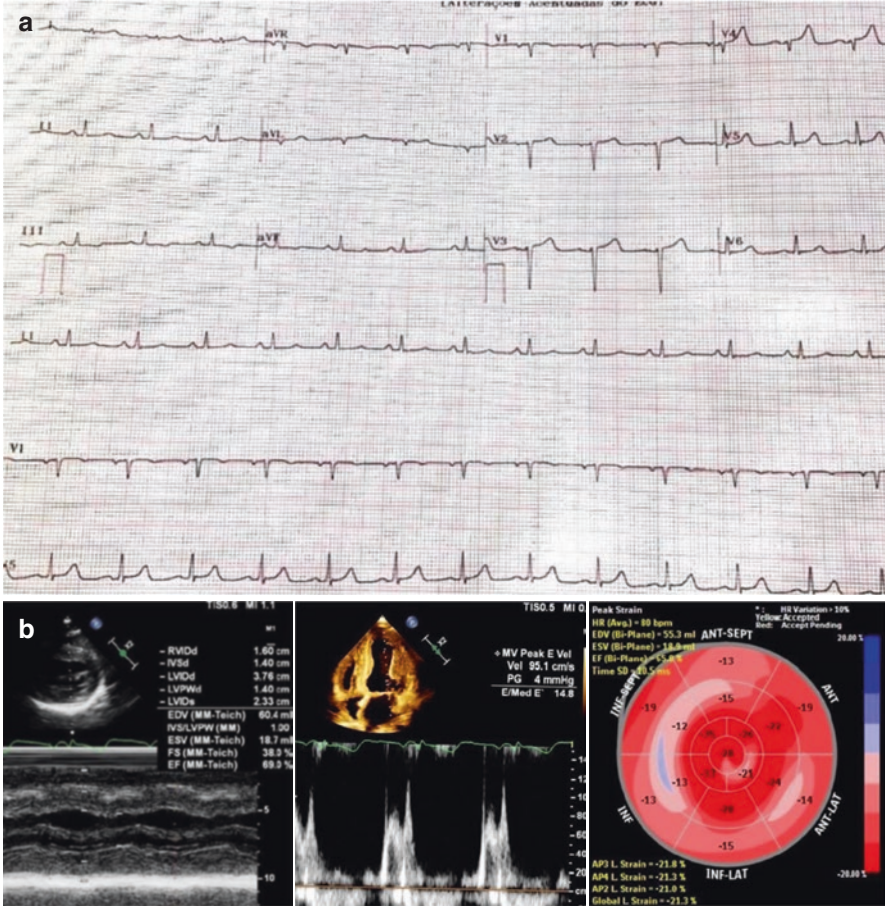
(a) Low-voltage limb leads without left ventricular hypertrophy voltage criteria despite increased wall thickness on echocardiography and pseudoinfarction in anterior precordial leads. (b) Apical sparing describes a reduced longitudinal strain in the basal segments and preserves the supranormal longitudinal strain in the basal segments of the left ventricle
